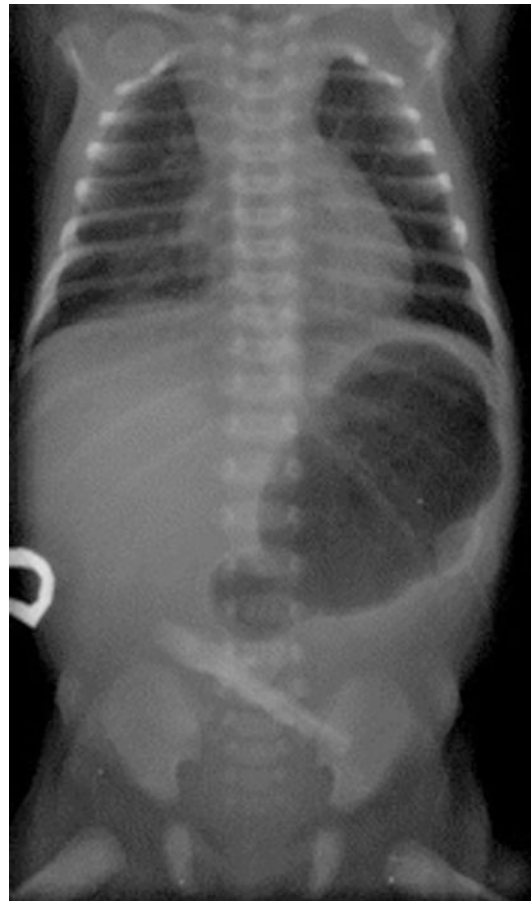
Typical 'single bubble' radiographic finding in pyloric atresia (Reproduced with permission from Darwish et al. [11])
